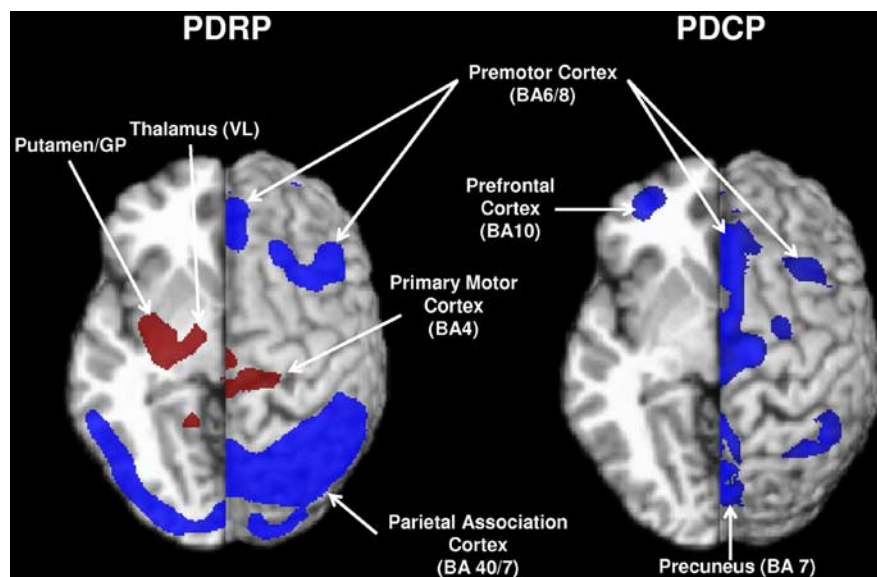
Left, PDRP (Ma et al., 2007) was characterized by pallidothalamic, pontine, and motor cortical hypermetabolism, associated with relative metabolic reductions in the lateral premotor and posterior parietal areas. Right, PDCP (Huang et al., 2007a) was characterized by hypometabolism of prefrontal cortex, rostral supplementary motor area, and superior parietal regions. Relative metabolic increases are displayed in red; relative metabolic decreases are displayed in blue. Both patterns were overlaid on a standard magnetic resonance imaging brain template. The left hemisphere was cut in the transverse plane at $z = -5$ mm. The right hemisphere was displayed as a surface projection on the same brain template. BA, Brodmann's area.
